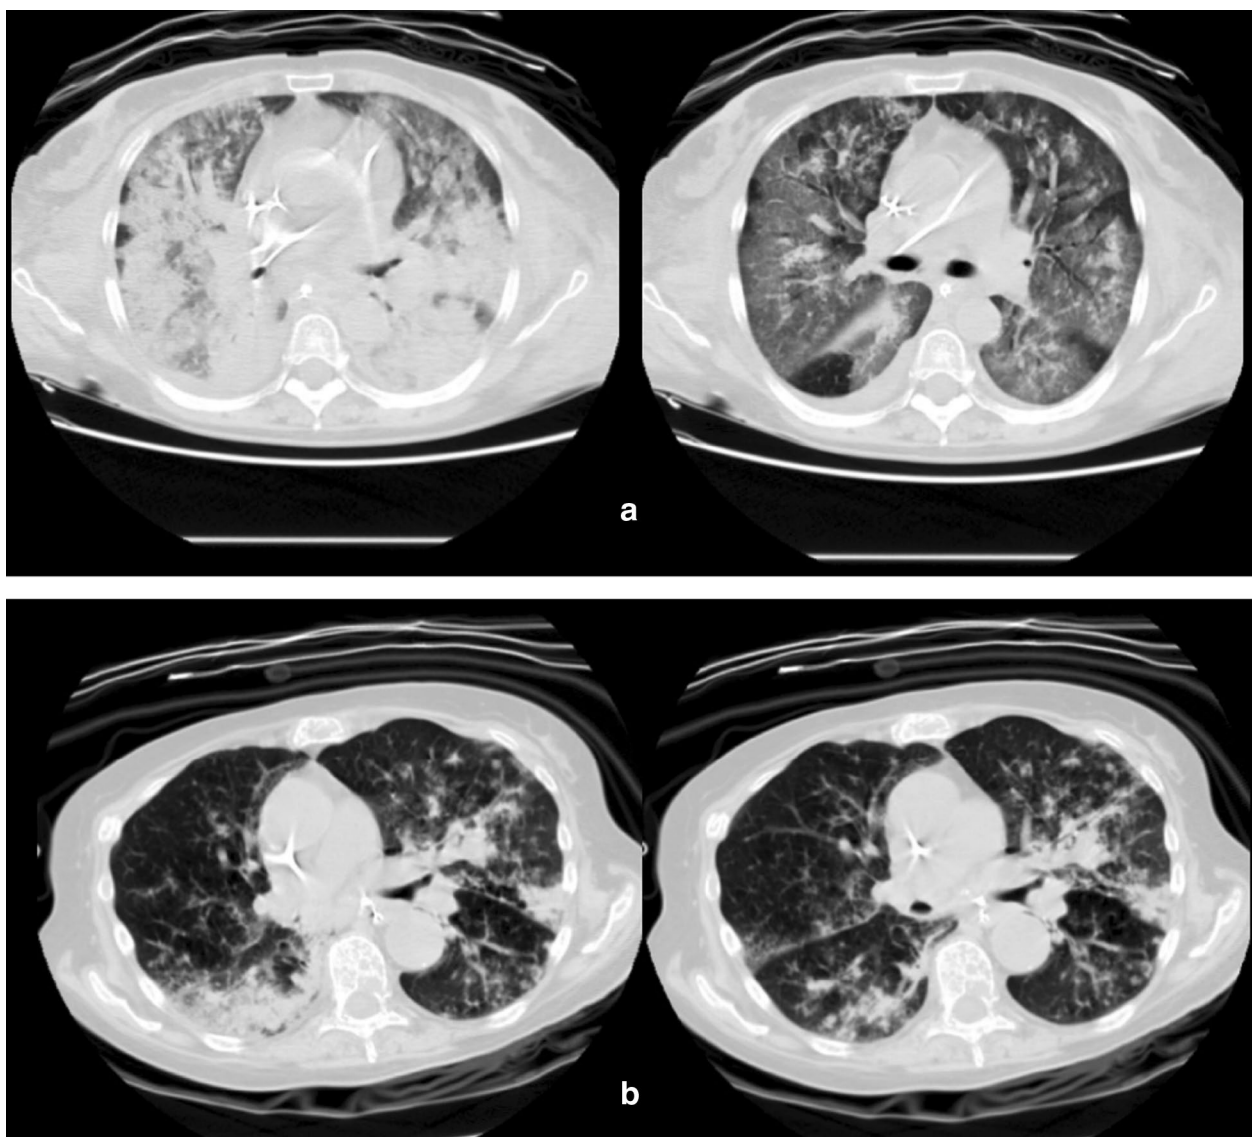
Representative CT scan imaging from two patients with ARDS. a Patient presenting with homogeneous opacities with a high potential for recruitment. b Patient presenting with lung inhomogeneity with a low potential for recruitment
